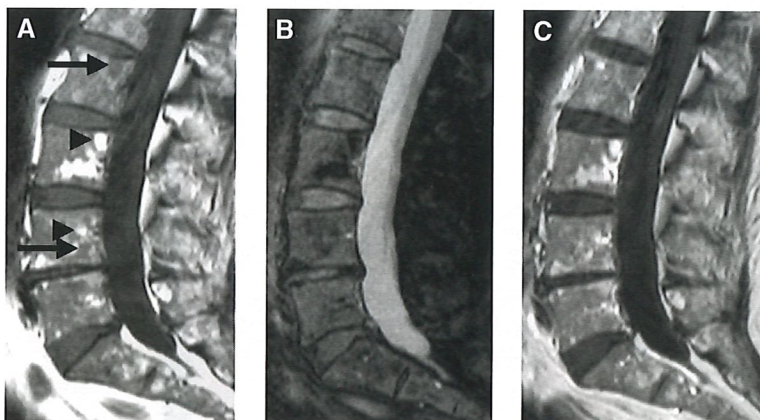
Heterogeneous marrow. (A) Sagittal T1-weighted SE and (B) fat-saturated intermediate-weighted fast spin echo (FSE) of the lumbar spine of a 73-year-old woman with breast cancer show heterogeneous marrow appearance with islands of fatty marrow (arrowheads) and small nodules of more cellular marrow (arrows). Areas of more cellular marrow also show intermediate signal on fat-saturated image. (C) On the gadolinium-enhanced sagittal T1-weighted image, moderate signal intensity enhancement can be seen. This signal pattern remains compatible with normal heterogeneous marrow. A biopsy of the iliac crest was performed during breast surgery and showed hypercellular reactive hematopoietic marrow devoid of neoplastic cells.
